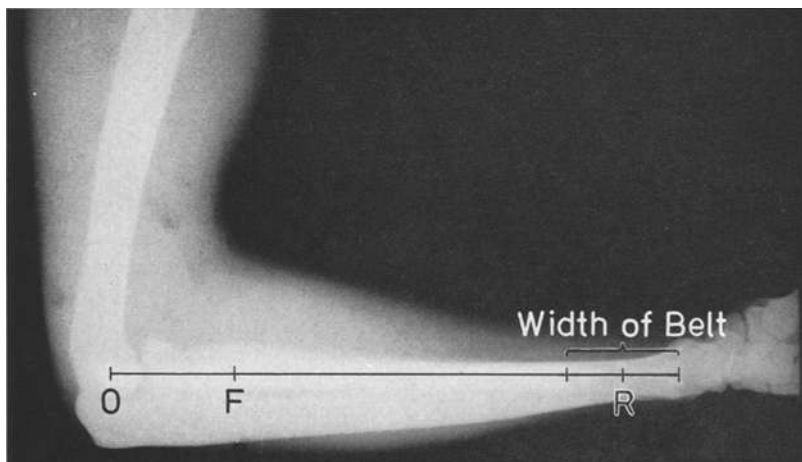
Determination of fulcrum (O), force point (F) and resistance point (R) by means of X-ray photograph
